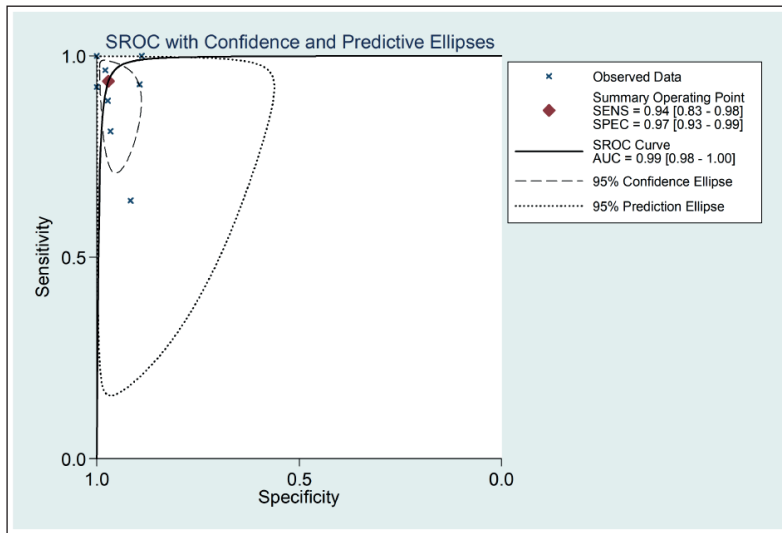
Summary receiver operating characteristic curves (ROCs) from the hierarchical summary receiver operating characteristic model generated from the 8 studies that found that multi-slice spiral CT as a diagnostic technique for acute mesenteric ischemic disease. Each solid circle represents an eligible study. The size of solid circle represents the sample size of each eligible study. The overall diagnostic efficiency is summarized by the regression curve.
